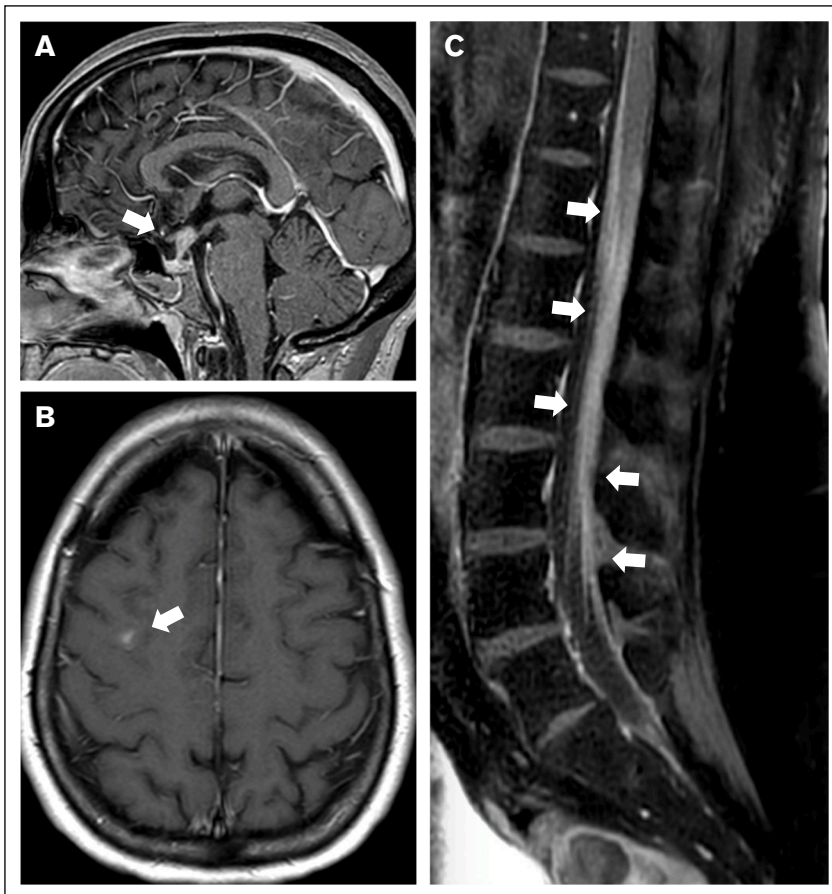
Magnetic resonance imaging diagnostic images from the presented case. (A) Sagittal T1-weighted brain scan with thickening and intense enhancement in the anterior aspect of the hypothalamus, involving the infundibular recess and the infundibulum. (B) Axial T1-weighted brain scan with a right frontal lesion with intense contrast enhancement. (C) Sagittal T1-weighted spine scan showing thickening and marked contrast enhancement of cauda equina roots.
